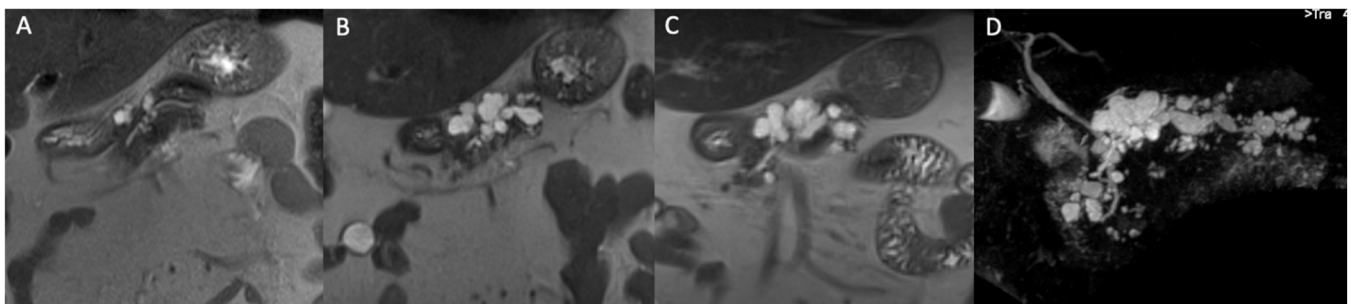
77-year-old man with IPMN and appearance of high-risk stigmata at follow-up. MR images in the coronal plane acquired in 2010 (A), 2021 (B) and 2022 (C and D), show multiple BD-IPMN that increase in number and size over time and appearance of dilatation of the main pancreatic duct over 10 mm in the last imaging follow-up.
